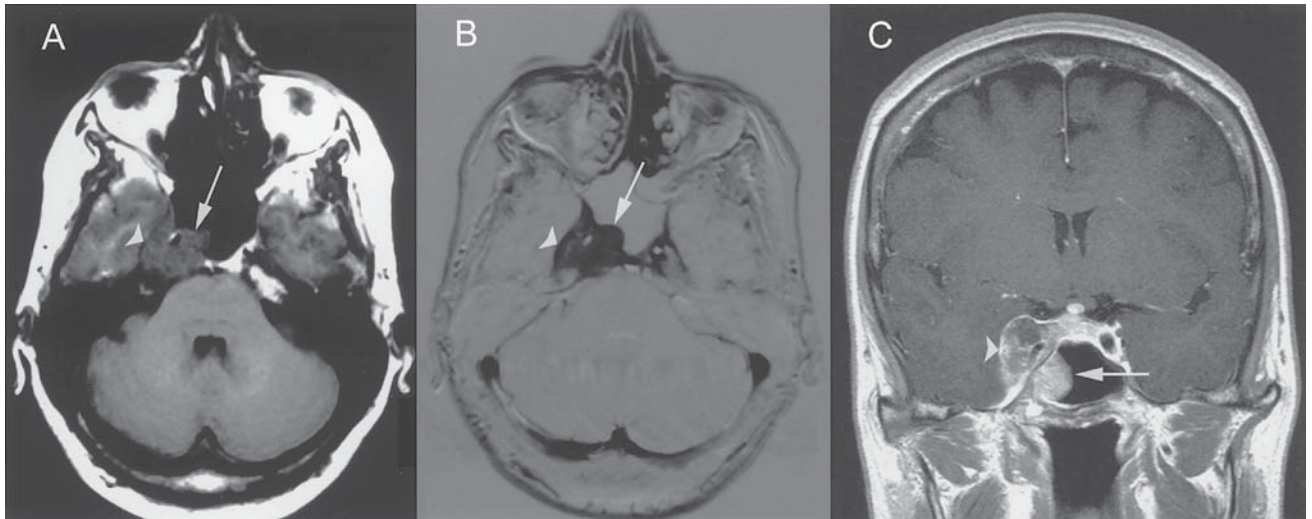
A woman with known breast cancer presented with horizontal diplopia followed by right-sided ptosis. There was complete ptosis and ophthalmoplegia with a dilated nonreactive pupil (7 mm) on the right. Sensation was normal in particular in the distribution of the first branch of the Vth cranial nerve. T1 weighted MRI images before (A) and after gadolinium (B,C; B: subtraction image) demonstrate a lesion in the right sphenoid bone extending into the sphenoidal sinus (arrow), middle fossa, and cavernous sinus (arrow head).
